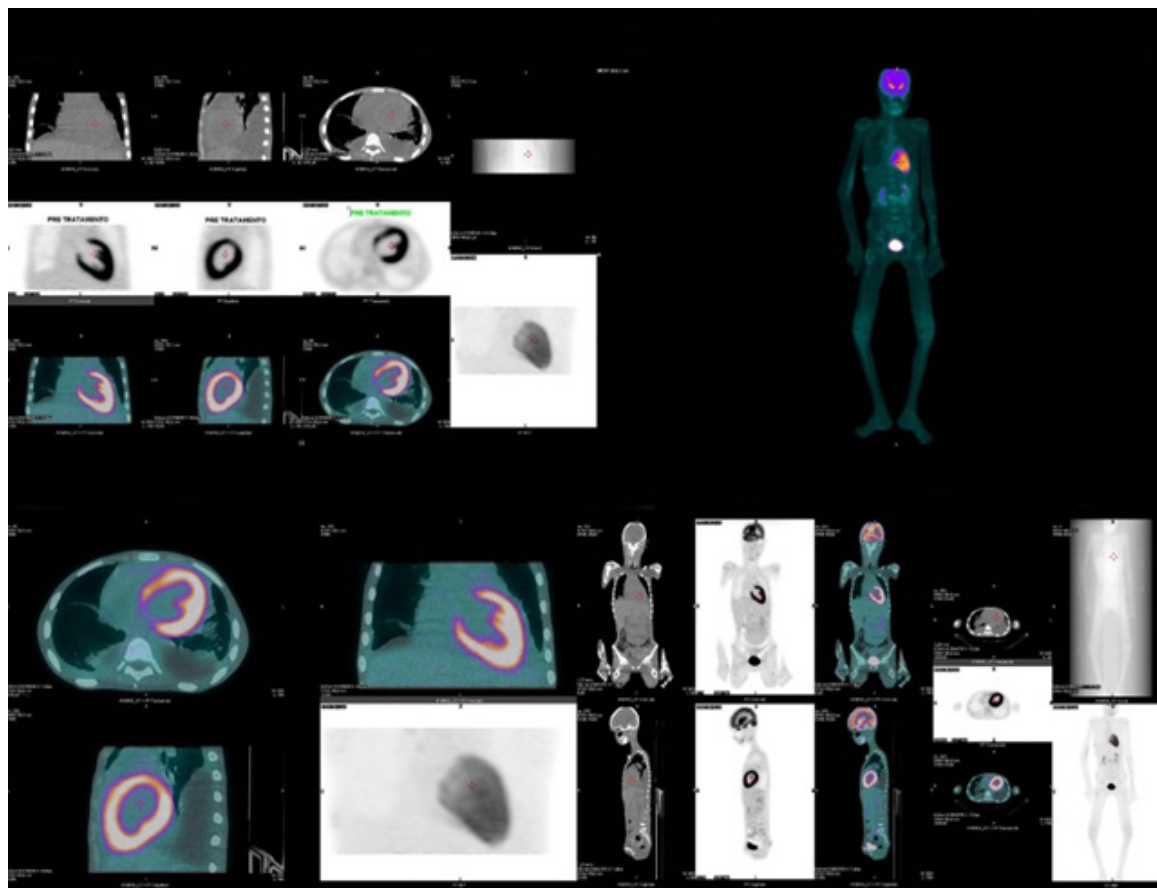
^{18}F -FDG PET/CT in pre-treatment lupus myocarditis: There is intense diffuse uptake of ^{18}F -FDG in the left ventricle, suggesting myocarditis.
